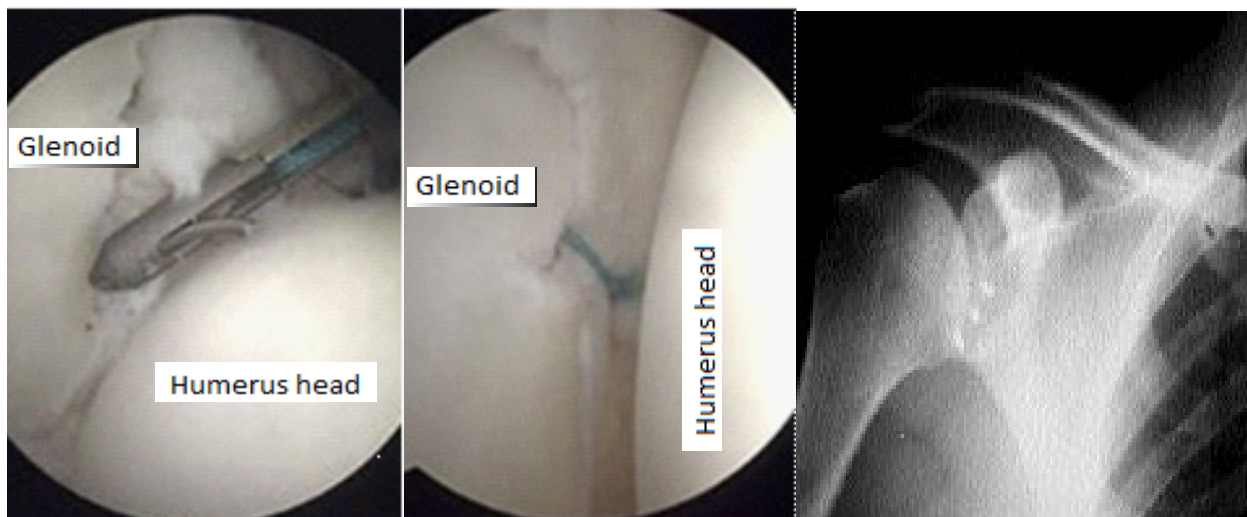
Arthroscopic view of Bankart repair with knotless anchor and postoperative radiography
